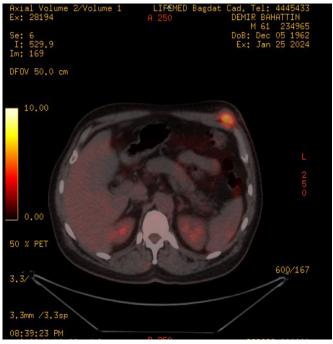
Positron emission tomography with computed tomography (PET-CT): Lung lesion with an SUV max of 4.8 and mediastinal lymphadenopathy. Additionally, multiple bone and soft tissue lesions were observed.
